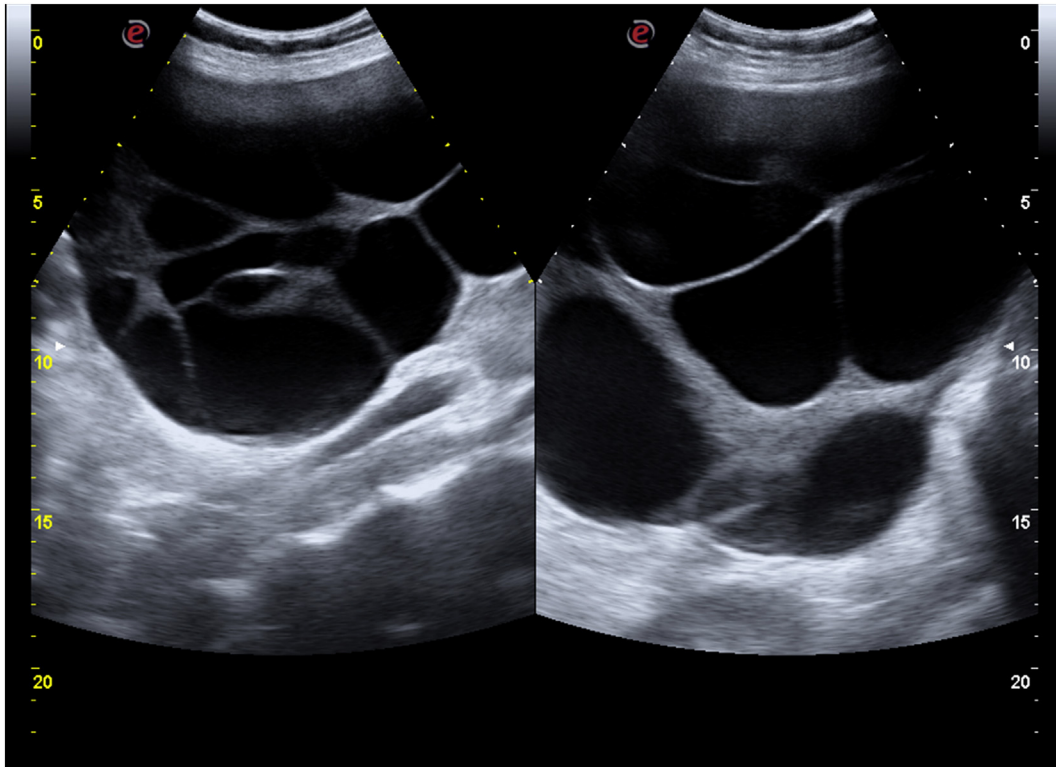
Transabdominal ultrasound at 13.5 weeks of gestation of the right ovary (a) and left ovary (b). Multiple theca lutein cysts forming an apparent “spoke wheel”.
